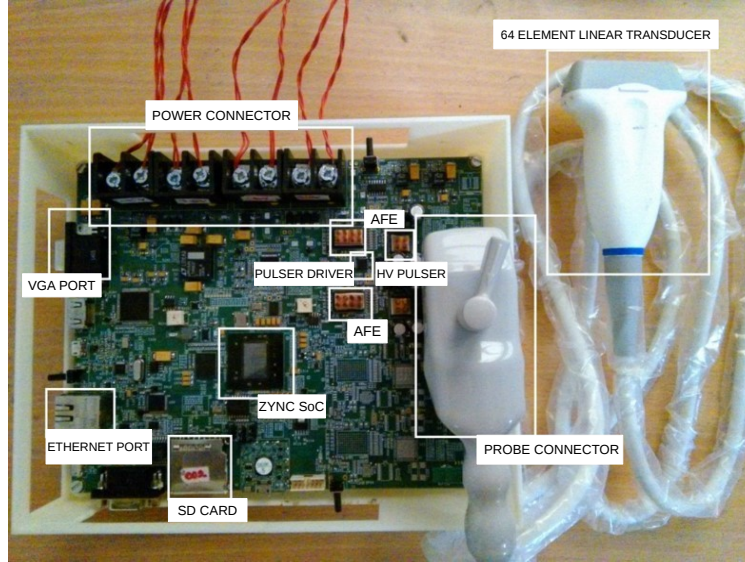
A Single SoC based programmable portable ultrasound scanner.
